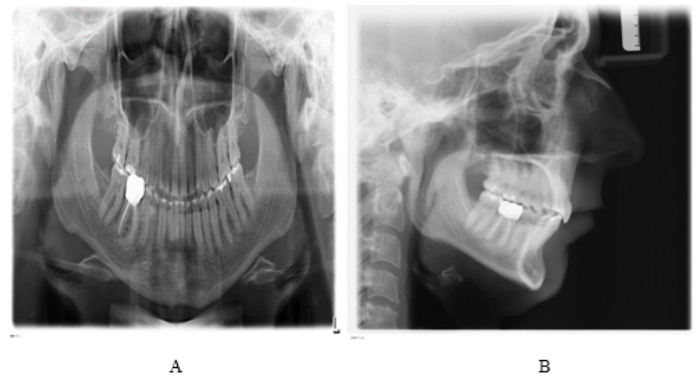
a) Panoramic radiograph at the end of treatment b) Cephalometric radiograph at the end of treatment.
